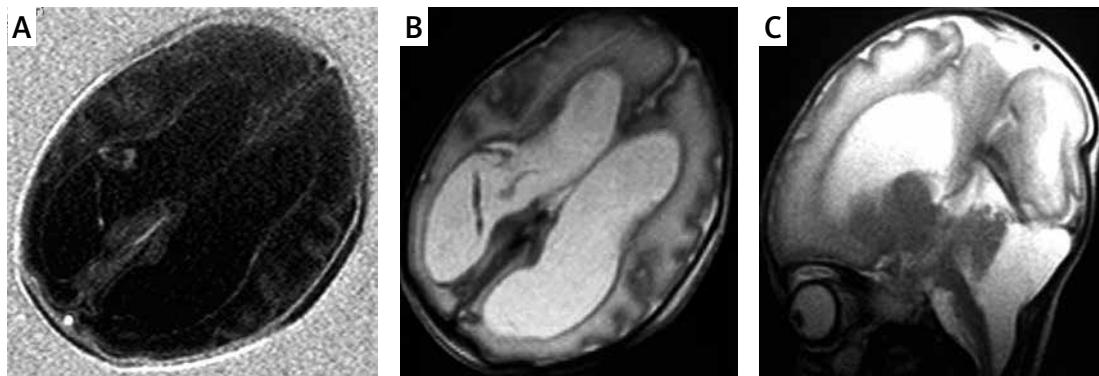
In the second patient, axial T1-weighted (A) and T2-weighted (B) images also showed lack of normal myelination for age, ventriculomegaly, hypoplasia of the corpus callosum, and retrocerebellar cystic dilatation (C)
